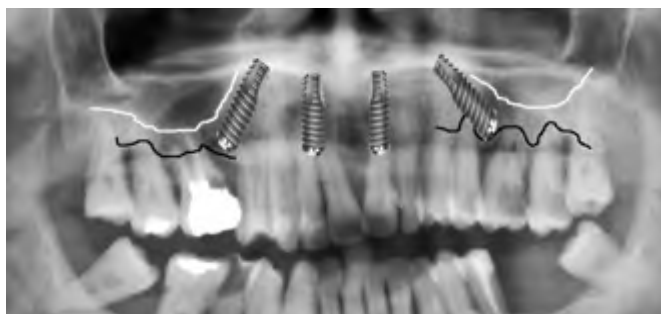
Preoperative panoramic radiograph with the floors of the maxillary sinuses (white) and the approximate location of the crestal bone immediately after posterior tooth extractions (black). Implants have been placed into tentative positions, based on the available bone. The posterior implants are tilted in order to increase their lengths.
